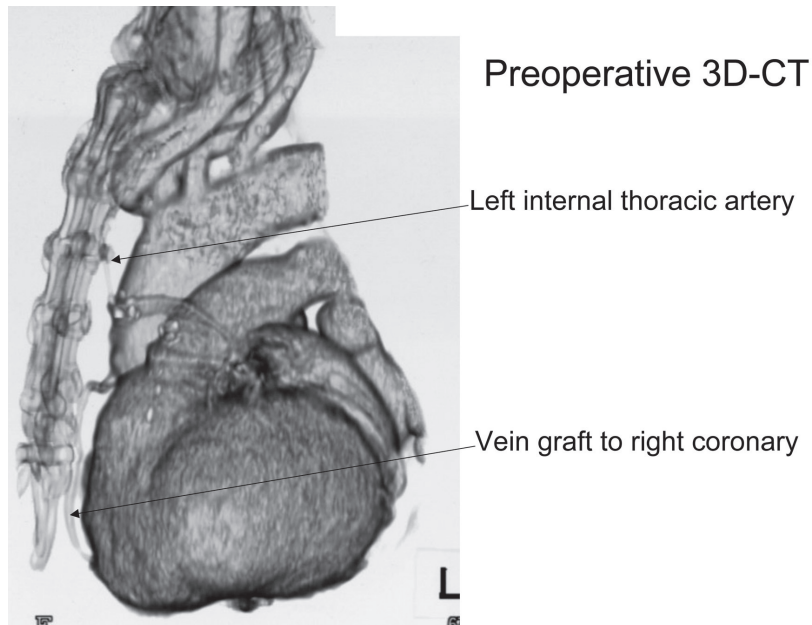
Three-dimensional CT showing the left internal thoracic artery and right coronary vein graft coursing behind the sternum.
